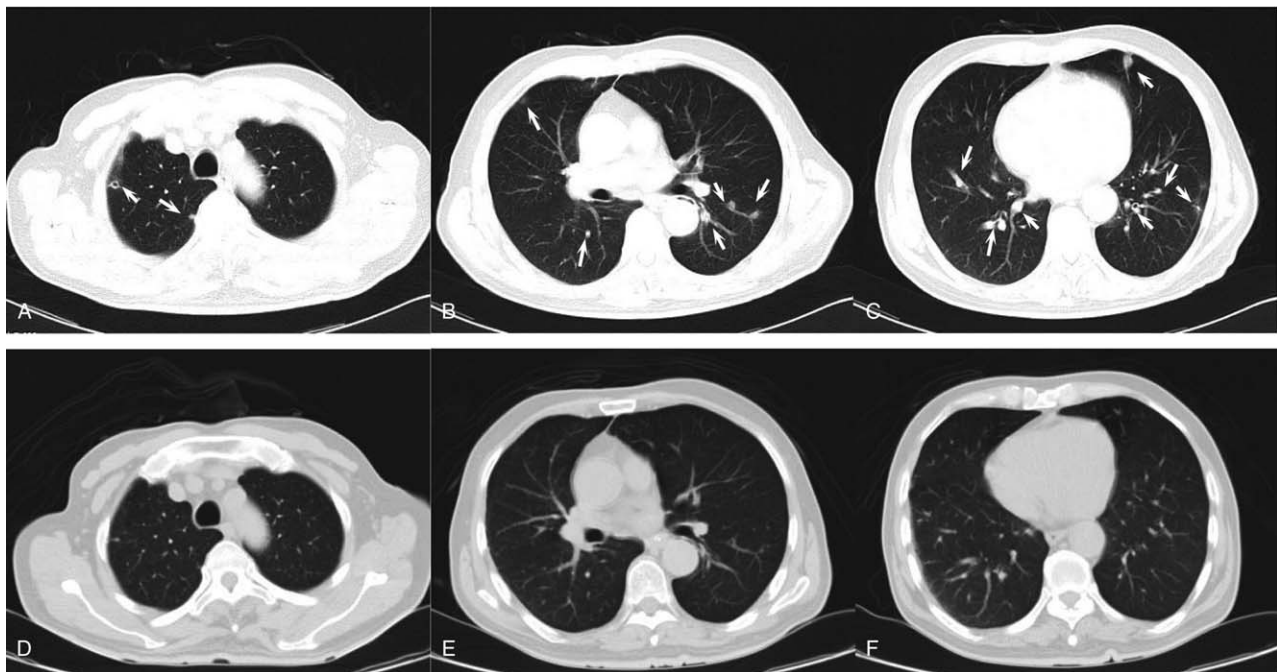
CT scan of the lung. (A, B and C) Initial CT lung images after hospitalization in our hospital. Multiple nodules and some with a small cavity were observed (marked with white arrows). (D, E and F) The follow-up CT lung images from 2 months later.
